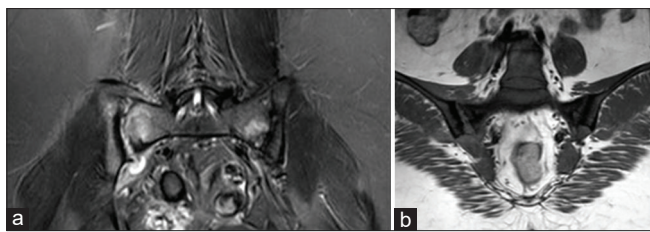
(a) STIR coronal section of the pelvis showing bilateral sacroiliitis with peripherally enhancing collection around bilateral sacroiliac joints (Right > Left). (b) T1-weighted magnetic resonance imaging image showing bilateral sacroiliitis with peripherally enhancing collection around bilateral sacroiliac joints (Right > Left)
